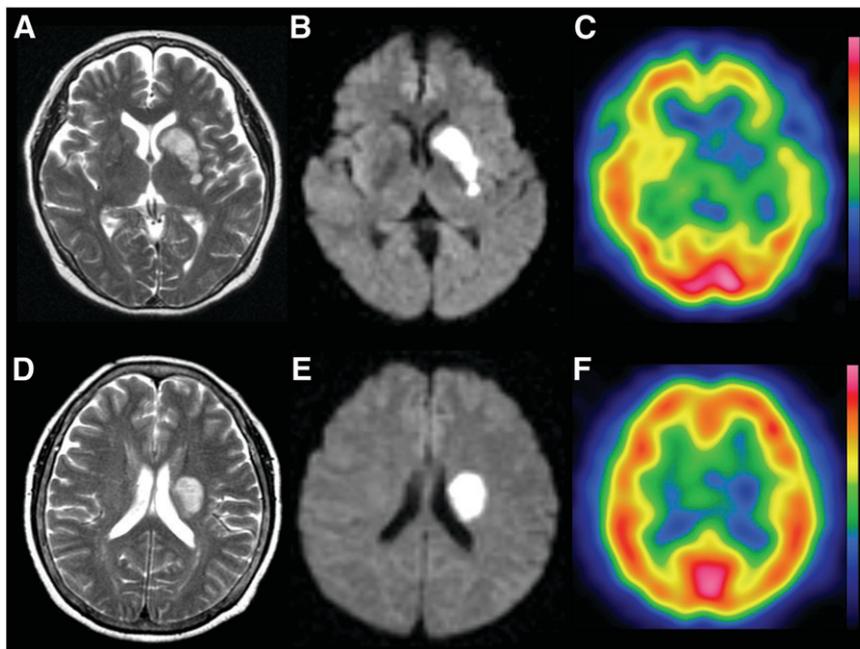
Representative images of T2-weighted MRI (A and D), diffusion-weighted MRI (B and E), and perfusion SPECT (C and F). (A–C) Patient with severe aphasia (AQ = 57.4 points) shows severe extensive left cerebral cortical hypoperfusion (AI of cerebral cortex = 14.93). (D–F) Another patient with mild aphasia (AQ = 90.9 points) had only mild hypoperfusion in left parietal cortex (AI of cerebral cortex = 2.53).
